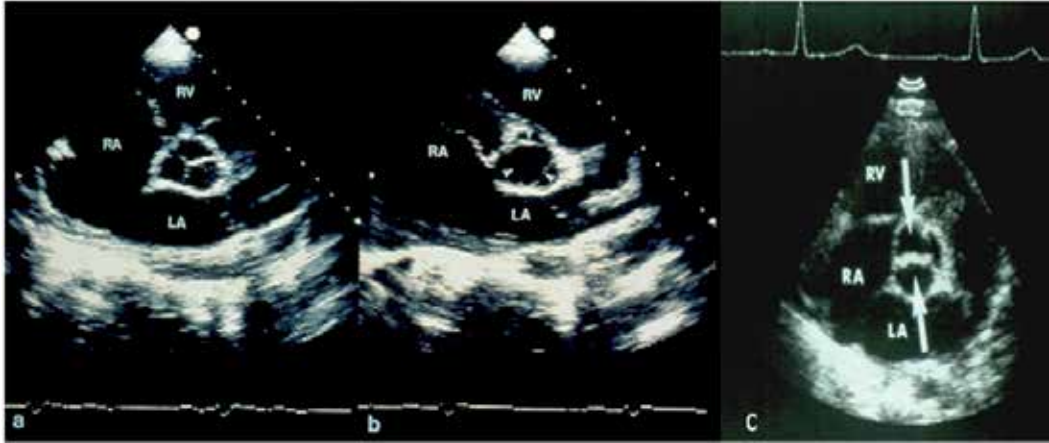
Short axis views of the aorta showing aortic valve leaflets in closed (a) and open position (b) in children with tricuspid aortic valves (a and b). Bicuspid aortic valve (large arrows) is shown in c, which is commonly associated with aortic stenosis. Three aortic valve cusps and commissures (in a) are clearly seen and contrast with two valve cusps and single horizontal commissure (in c). Arrow heads in b point to open aortic valve leaflets. Neither of the children showed clinical or echo-Doppler evidence for aortic stenosis and are shown here only to demonstrate the bicuspid and tricuspid valve leaflets. LA, left atrium; RA, right atrium; RV, right ventricle.
